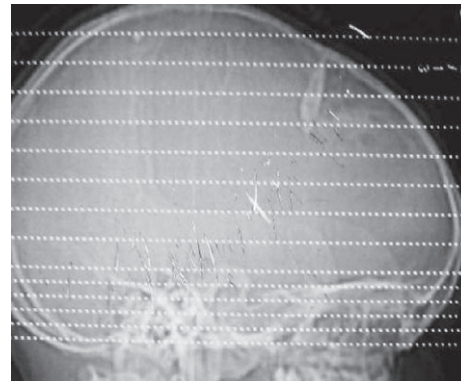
Scout film of CT head showing the impacted incisor.
